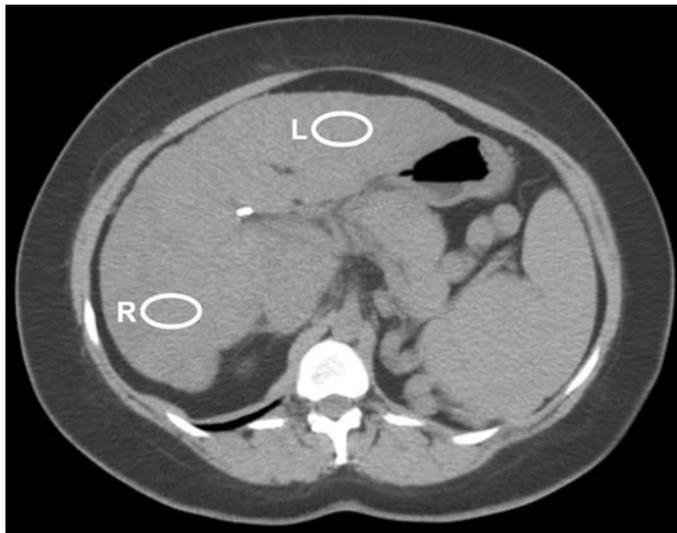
Measurement of liver parenchymal attenuation. The CT image demonstrates the regions-of-interest in the right (R) and left (L) hepatic lobes.
